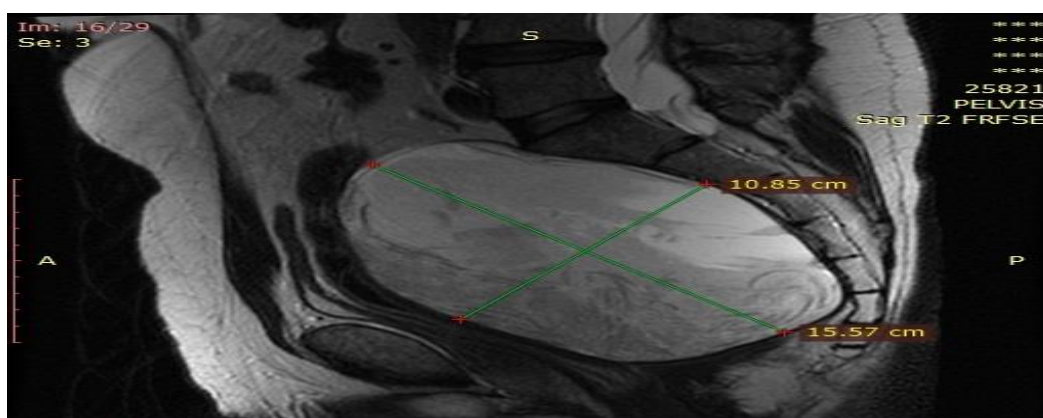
T2 weighted sagittal image of the tumor on MRI
